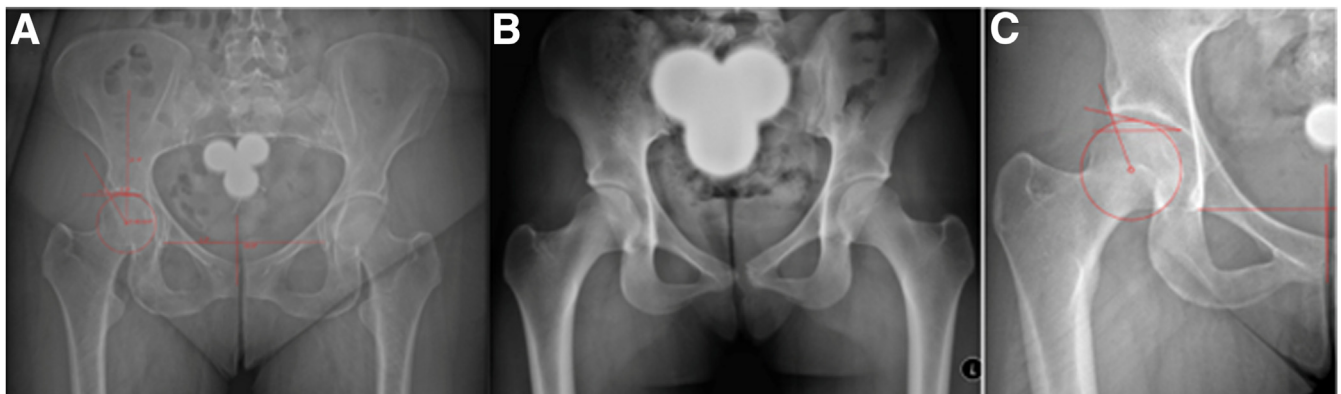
Radiographic measures obtained: lateral center-edge angle and Tönnis angle with positive posterior wall sign (A), positive crossover sign (B), and Tönnis angle with positive ischial spine sign (C).
